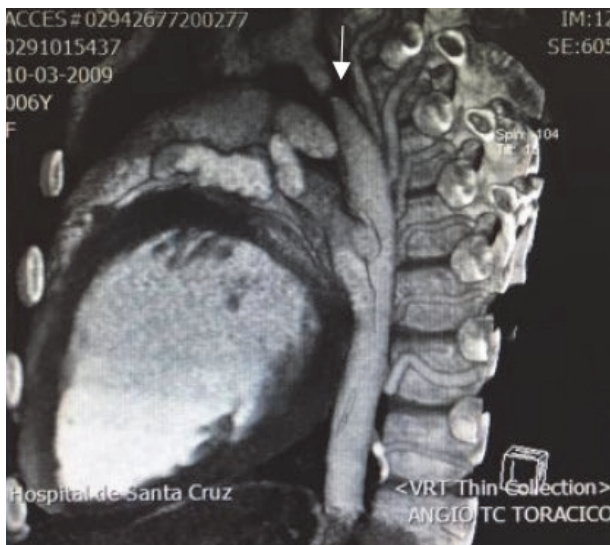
Computed tomography angiography: Post-isthmic coarctation of the thoracic aorta.
